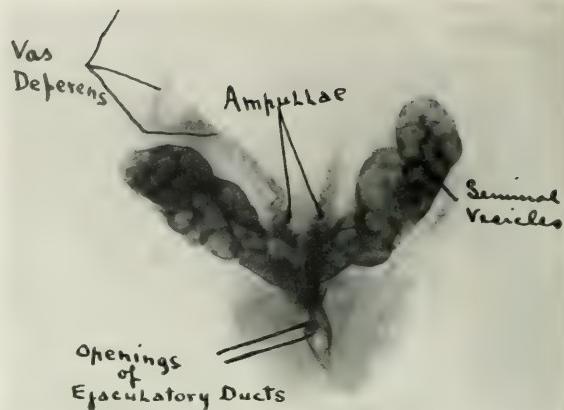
Showing the anatomical arrangement from an X-ray point of view.
